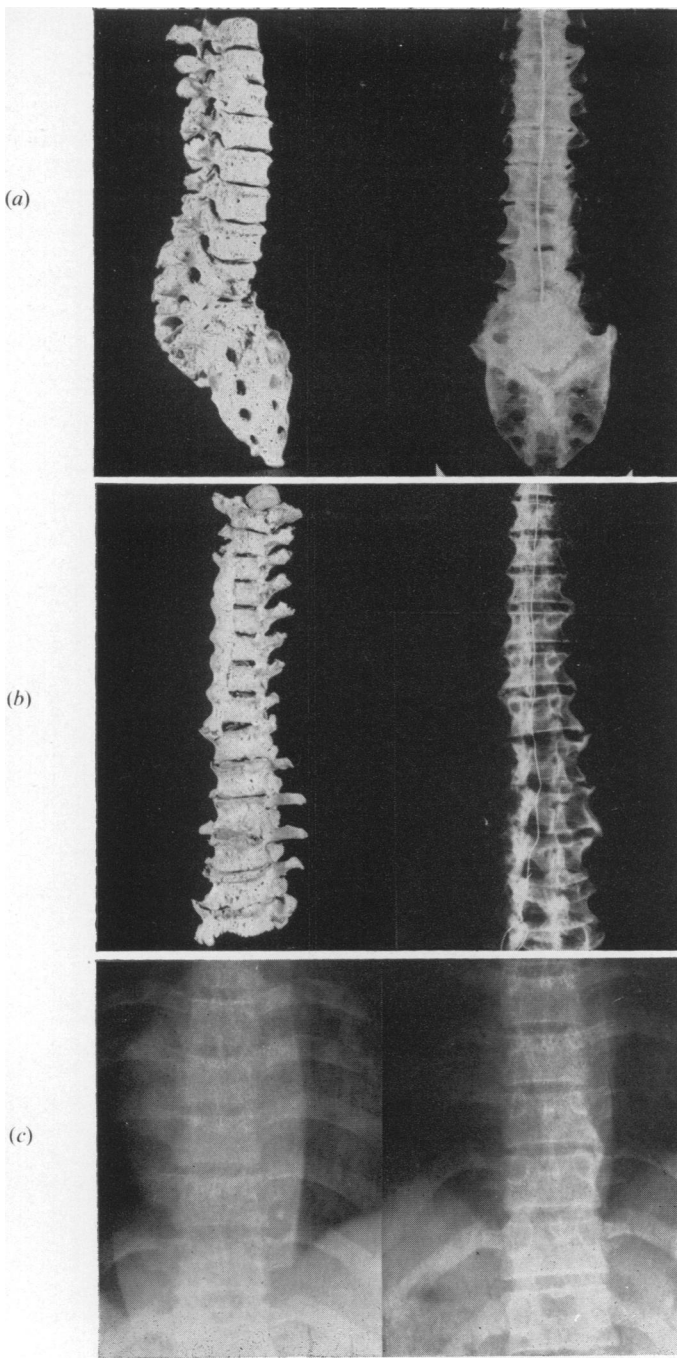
(a) Tuberculosis of the lumbar and sacral spine with bridging in the dorso-lumbar segment. (b) Unilateral thoracic spondylosis with hypertrophic changes in other parts of the spine. (c) X-rays showing formation of a bridge in a shrinking abscess.
